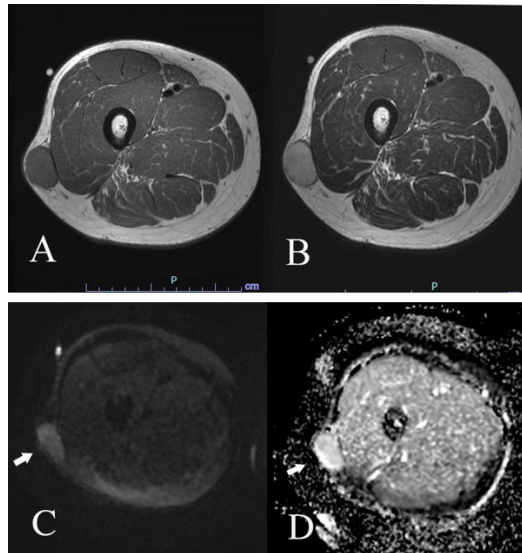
Case 1. Angiofibroma of soft tissue in the lateral thigh. Axial T1-weighted MRI (TR/TE=825/12.42) demonstrates a well-circumscribed subcutaneous mass adjacent to the femoral fascia with homogeneously slightly high signal intensity compared to the muscle (A). Corresponding axial T2-weighted MRI (TR/TE=4000/82.46) reveals a mass to be homogeneously high signal intensity (B). Axial diffusion-weighted imaging (DWI) (TR/TE=4000/61) shows hyper intense mass (C), and apparent diffusion coefficient (ADC) map also shows high signal intensity (D).
